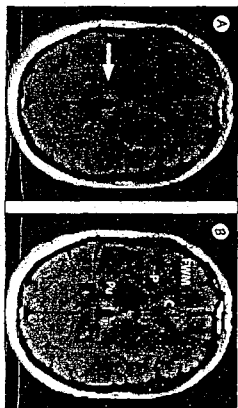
MRI (A) Increased signal intensity in the pulvinar nuclei bilaterally (arrow). (B) MRI signal intensity in the pulvinar (P) is higher than in the head of the caudate nuclei (C). pulvinar (P) and right frontal white matter (FWM).
